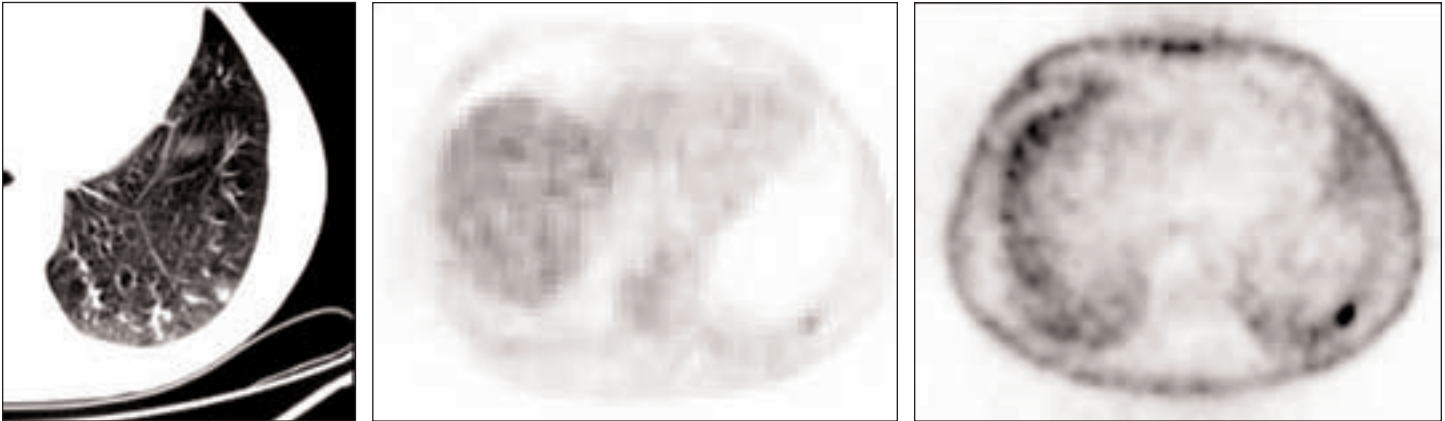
New 6-mm left lower lobe pulmonary nodule (left) is seen in 50-year-old man with stage III truncal melanoma. Attenuation-corrected image (middle) reveals low-level activity (SUV 1.8). Focus is more conspicuous on non-attenuation-corrected images (right). This was interpreted as consistent with metastatic disease due to high-risk staging of patient. The oncologist recommended tissue sampling to confirm diagnosis, then switched therapeutic regimens based on pathology showing metastatic melanoma.
